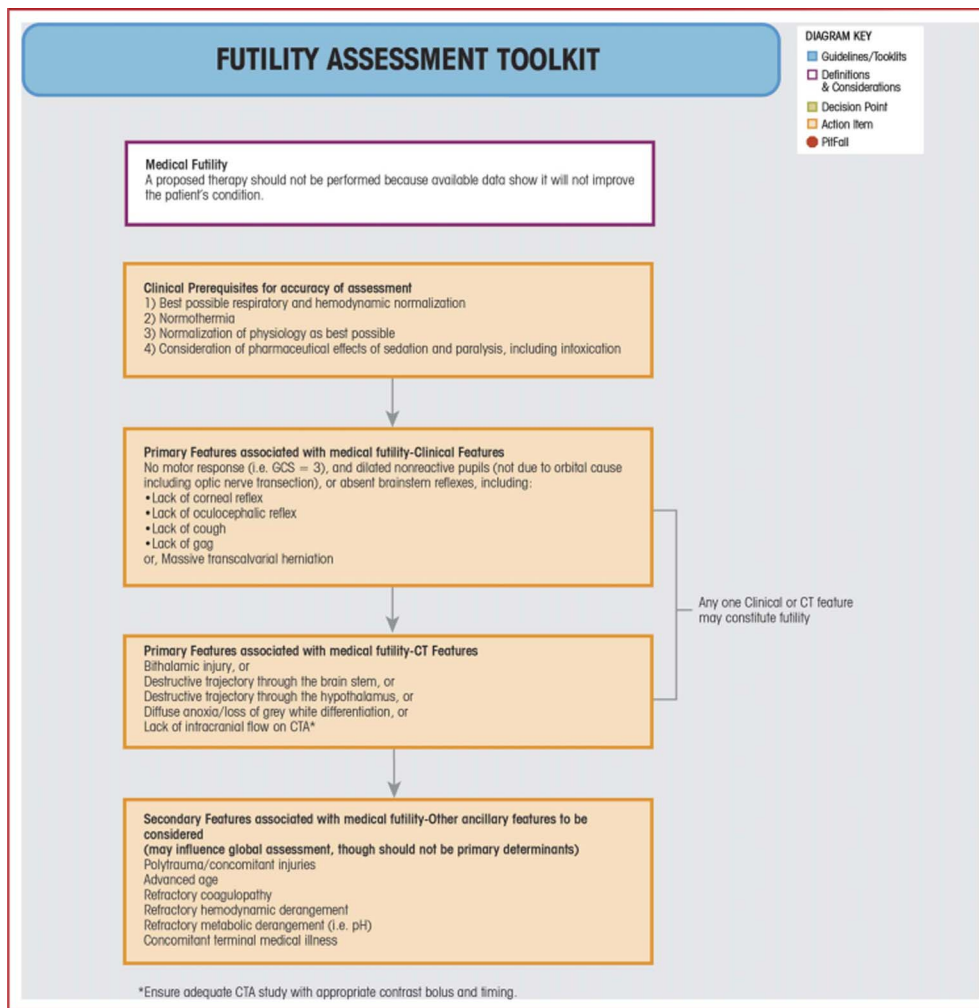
Futility Assessment Toolkit: clinical and radiographic indicators of futility.
